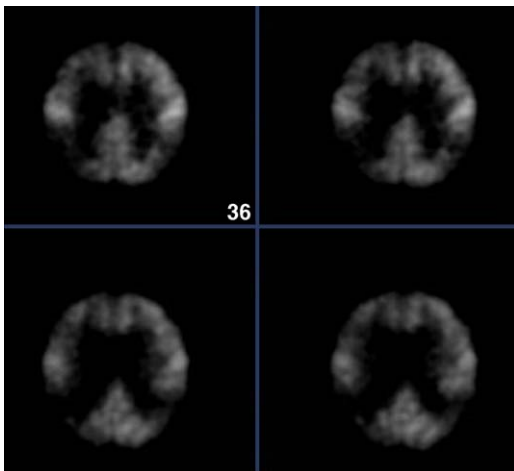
FDG-PET scan of a patient with advanced Alzheimer's disease. The findings demonstrate significant bilateral temporoparietal hypometabolism in addition to frontal lobe hypometabolism. The sensorimotor areas, visual cortex, and cerebellum are relatively preserved.
